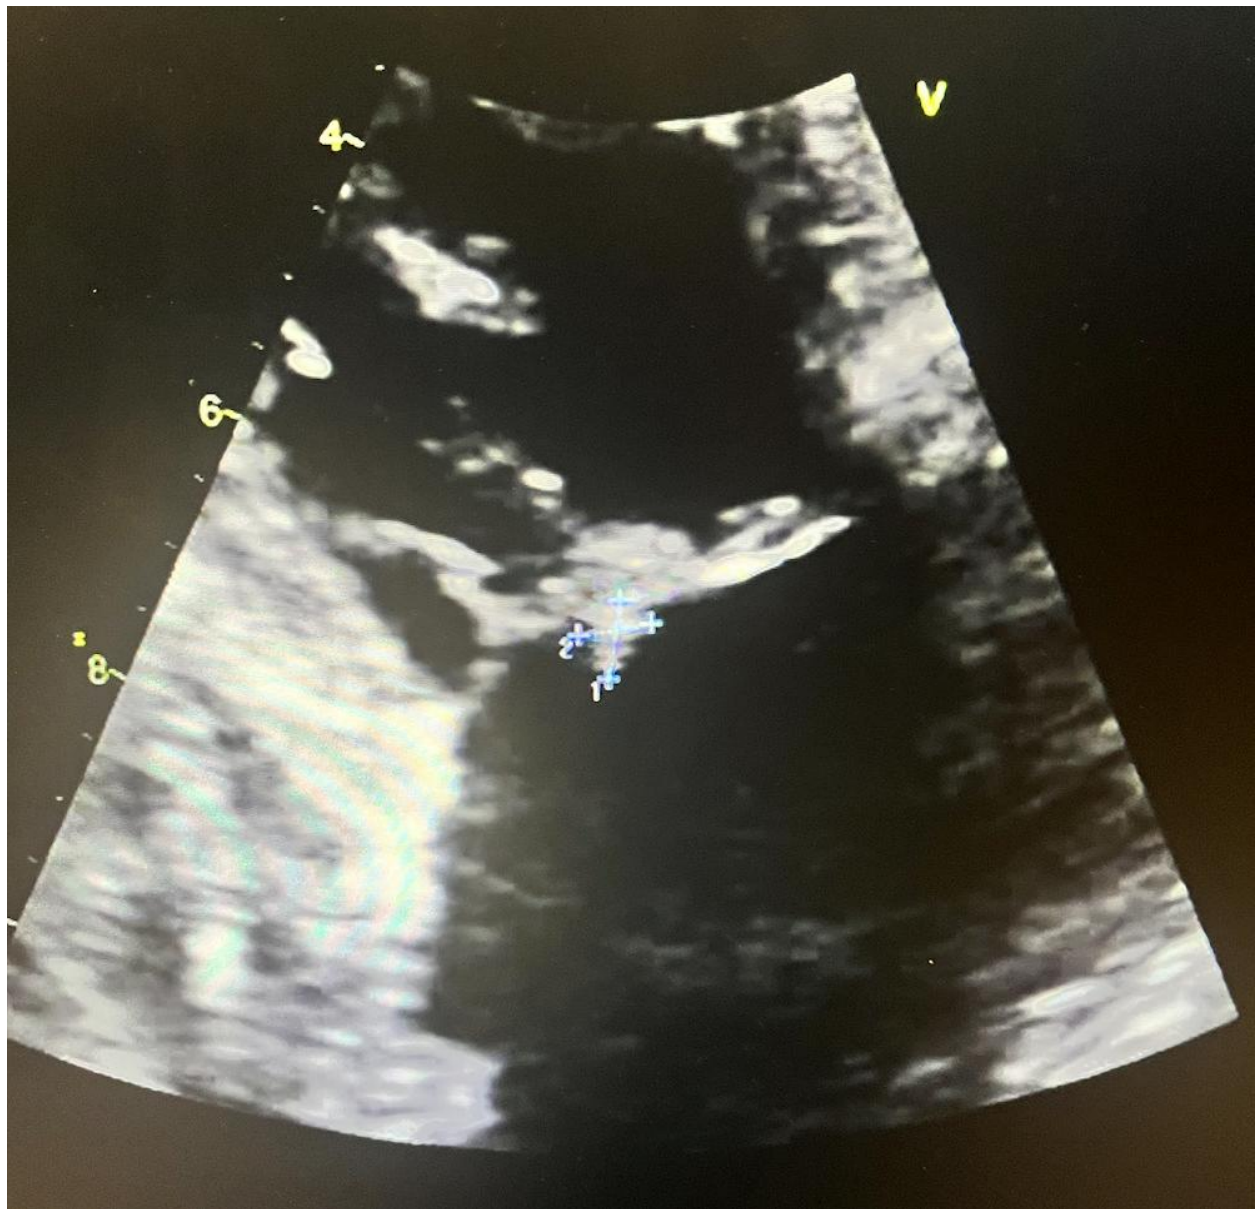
Transthoracic echocardiogram depicting tricuspid valve 0.5 cm (W) x 0.6 cm (L) vegetation.
